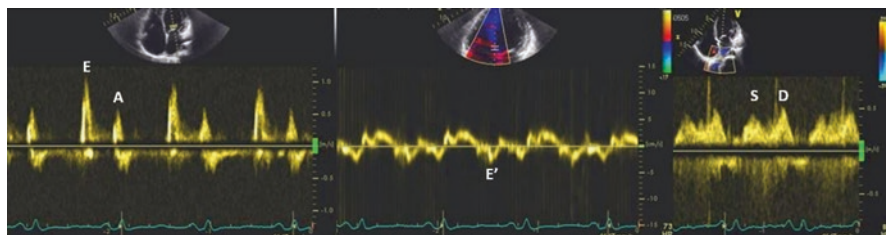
Diastolic dysfunction grade III in same patient from Fig. 8.2 with active lymphocytic myocarditis and heart failure presentation. Left panel: Mitral valve inflow spectral Doppler shows an $E/A > 2$. Mid panel: left ventricular septal tissue Doppler shows reduction in relaxation (septal $e' < 7$ cm/s) and increase in left ventricular end-diastolic pressure ($E/e' = 17$). Right panel: Reduced (< 1) S/D ratio in pulmonary venous flow is shown (indirect sign of elevated left ventricular filling pressure)
